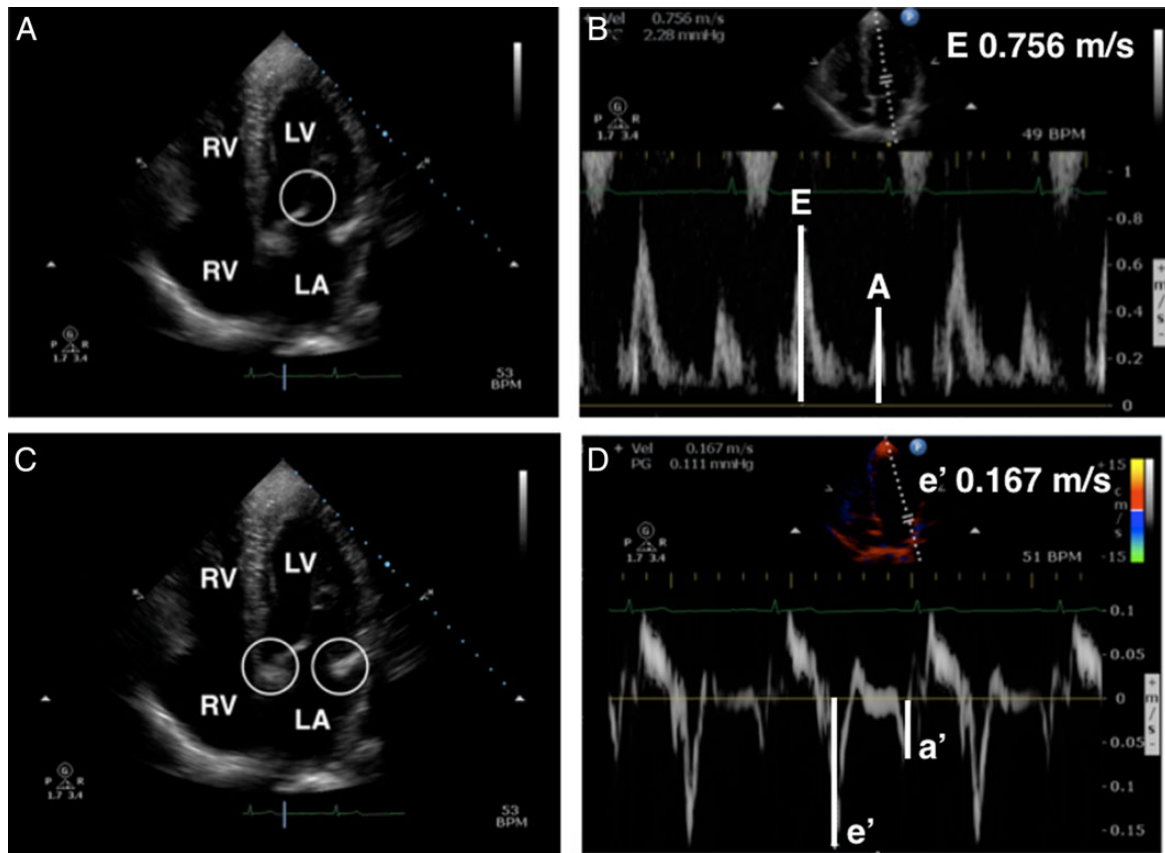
A4C and Doppler images required for measurement of E and e'. (A and B) The circle represents the required position for mitral inflow Doppler sampling (E) at the tip of the MV leaflets. (C and D) The circles represent the required position for TDI sampling (e') at the medial and/or lateral MV annulus.
